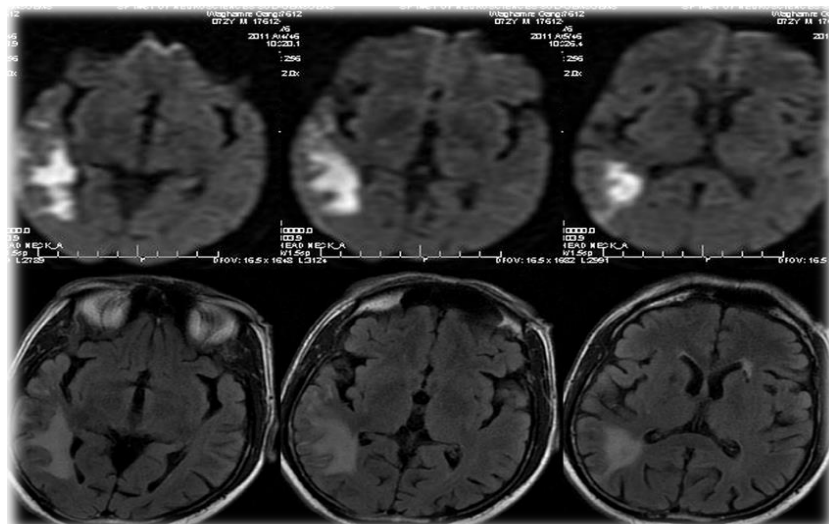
Brain abscess shows high signal on DWI and iso intense signal on T1 –weighted image.
